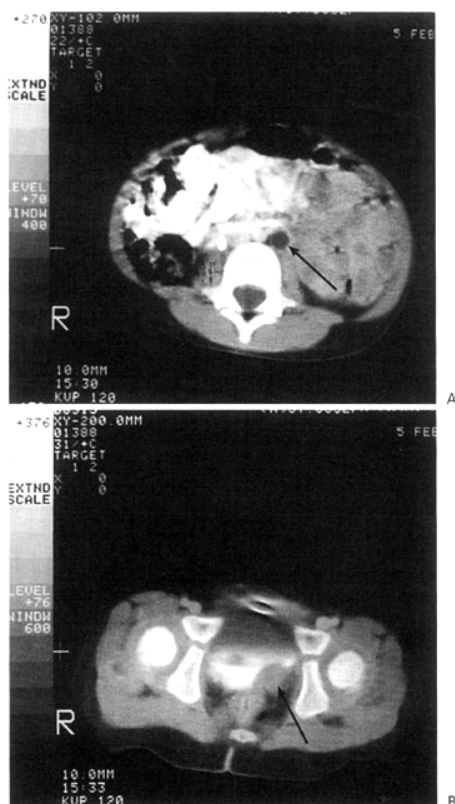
20. A: Secondary obstructed megaureter owing to tumor. Computed tomography scan shows hydronephrosis and enlargement of left ureter (*arrow*). B: Tumor recurrent at bladder wall at ureterovesical junction (*arrow*).
